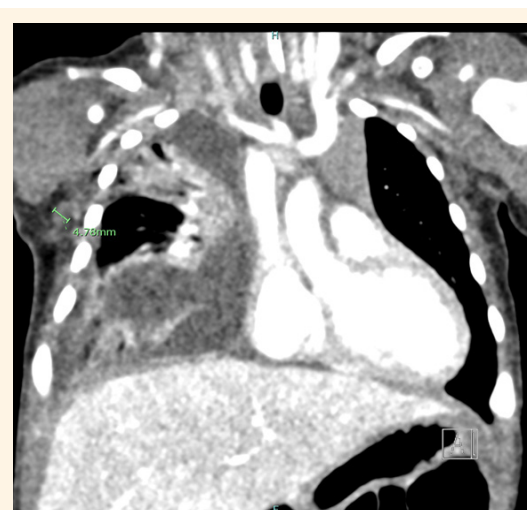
Computed tomography of the chest of a two-month-old male infant showing large right-sided pleural effusion which appeared to be encysted in apical region, causing compressive atelectasis of the right lung and causing shift of cardiomedastinal structures to the contralateral left side.
